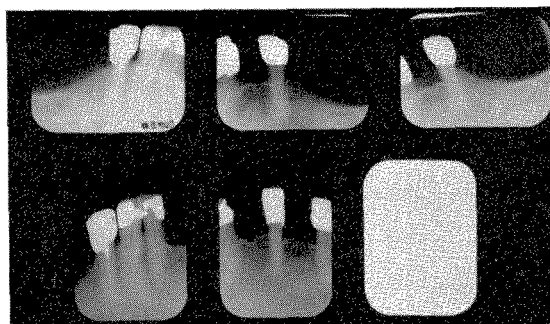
Roentgenograms of the lower teeth taken in 1962. The bone structure was still in excellent condition.
